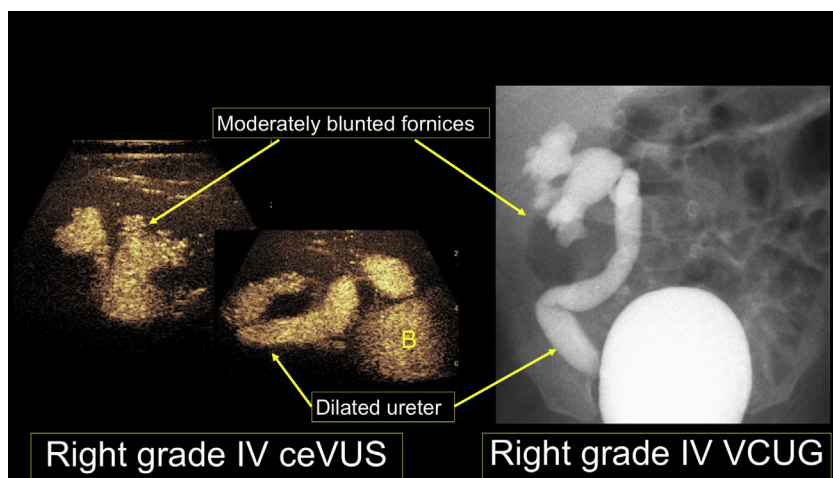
Grade 4 vesicoureteral reflux demonstrated on both contrast-enhanced ultrasound (left) and fluoroscopic VCUG (right). Bladder (B). VCUG, voiding cystourethrogram.
